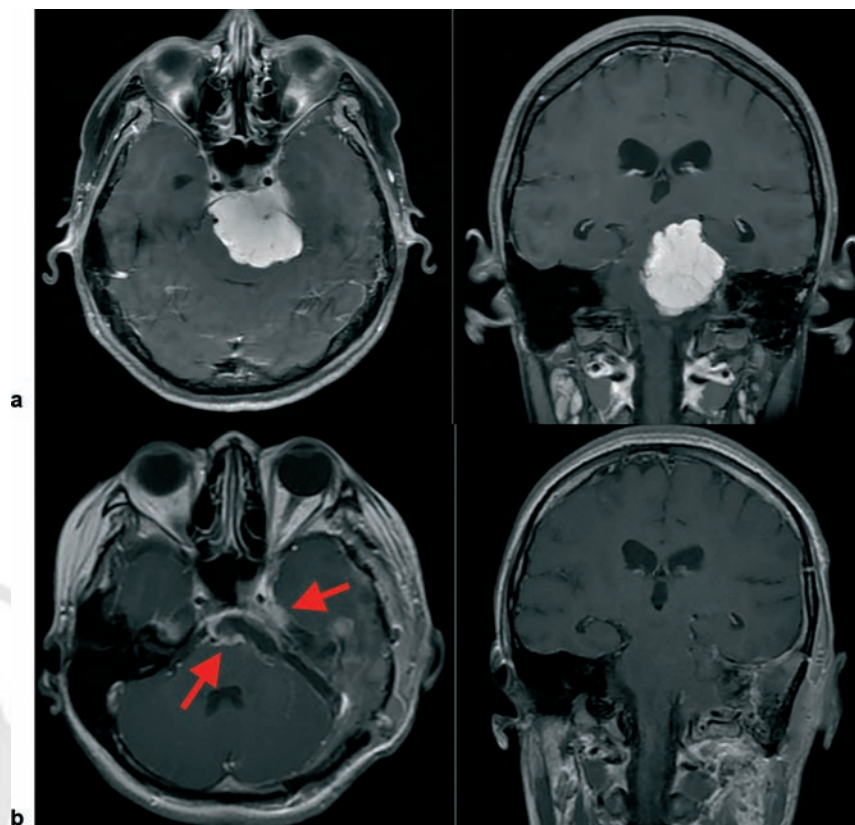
(a) Preoperative magnetic resonance imaging (MRI). Within the left petroclival region, there is a homogenous contrast-enhanced extra-axial mass with dural tail. A supratentorial extension of the mass was found in this case. The mass extends to the inferior clivus inferiorly and causes grade 3 brainstem compression. (b) Postoperative MRI showed residual tumor in the cavernous sinus and at the brainstem surface (red arrows).
